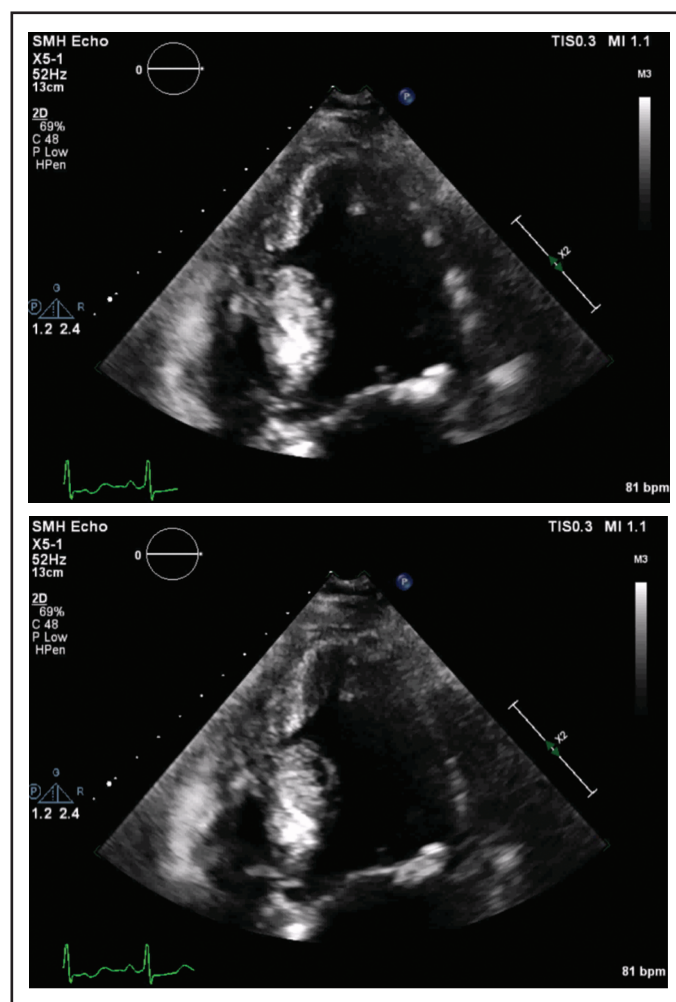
Muscular diverticulum 4-chamber (end-diastole and end-systole). Apical 4-chamber view depicting a muscular diverticulum, characterized by a finger-like protrusion into the inferoseptal wall of the LV. Mechanical activity is synchronous with the contractile function of the LV.⁶ The diverticulum preserves its size and shape throughout the cardiac cycles, showing no aneurysmal or dyskinetic wall motions.⁷
